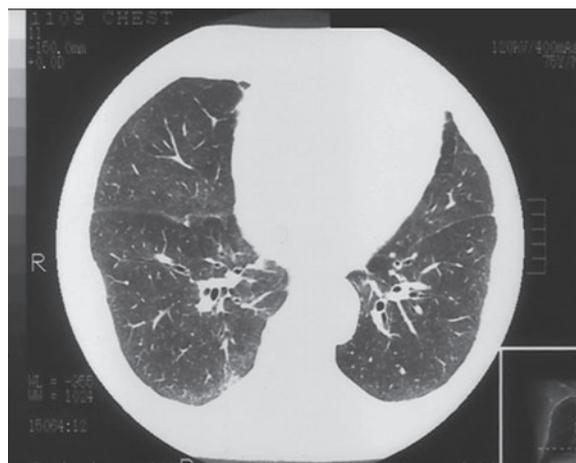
HRCT – ground glass type lesions – central and peripheral; mild in the upper pulmonary fields, more pronounced in the lower fields.
